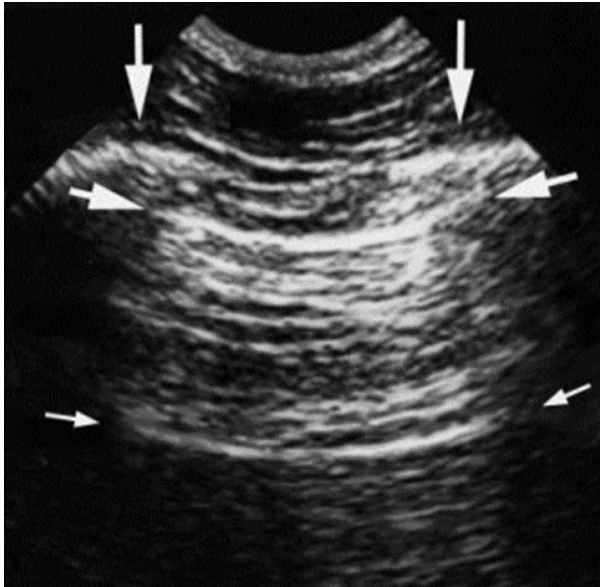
Ultrasound image of the intercostal space with the ribs shown by the vertical arrows. Rib shadows are displayed below. The upper horizontal arrows represent the pleural line, and the lower horizontal arrows represent the artifact of the pleural line, called the A-line. [Normal lung surface](#) by Daniel A. Lichtenstein licensed under [CC BY 2.0](#)
